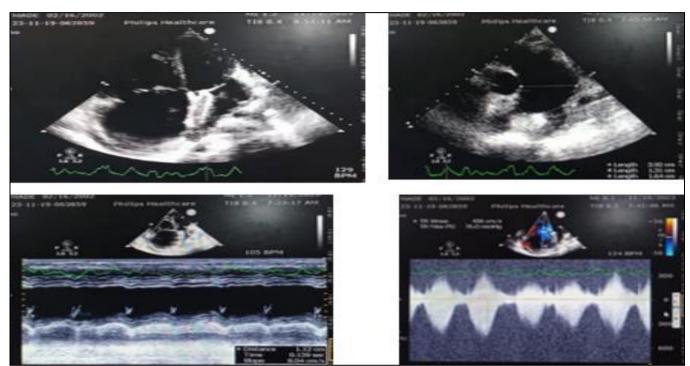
Echocardiography Findings
